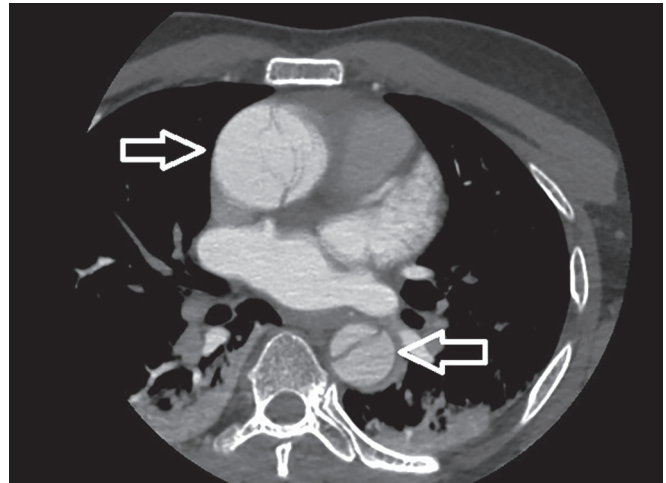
Computed tomography angiography neck vessels showing aortic dissection involving the ascending aorta and descending aorta
